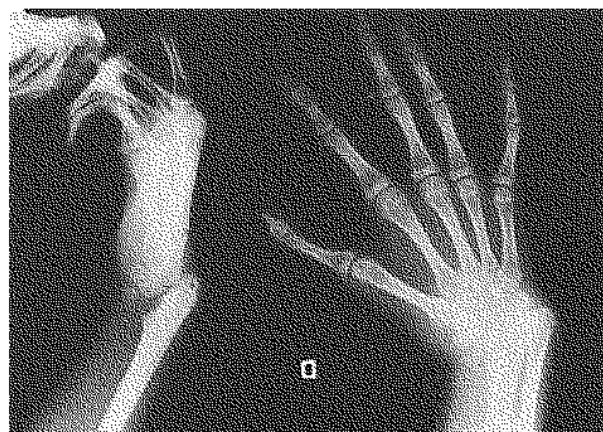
Radiograph of the hand.
